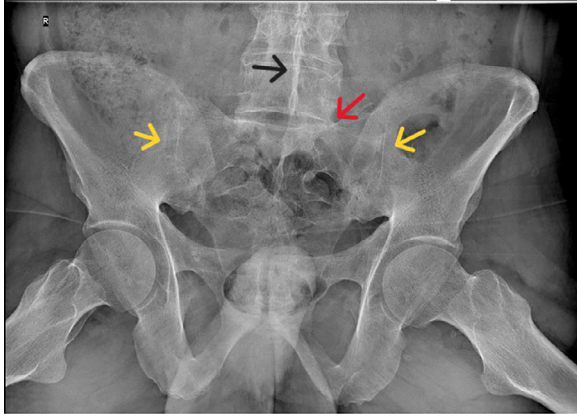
X-ray of the sacroiliac joint showing bilateral sacroiliac ankylosis (yellow arrow), left sacralization of L5 (red arrow), calcification of the supraspinous and interspinous ligament, the dagger sign (black arrow).
